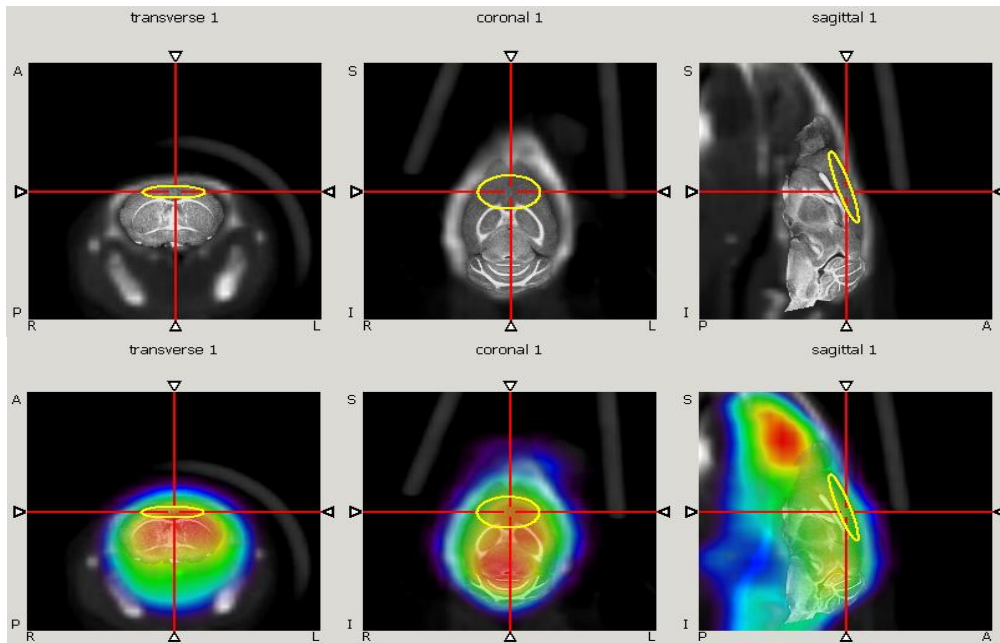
The first and the second rows are composed of 3 images; transverse, coronal and sagittal respectively. The first row shows the registration of CT and the brain atlas images. The second row shows the registration of PET/CT with the brain atlas. The 3D ROI shows the localization of the cerebral cortex region.
